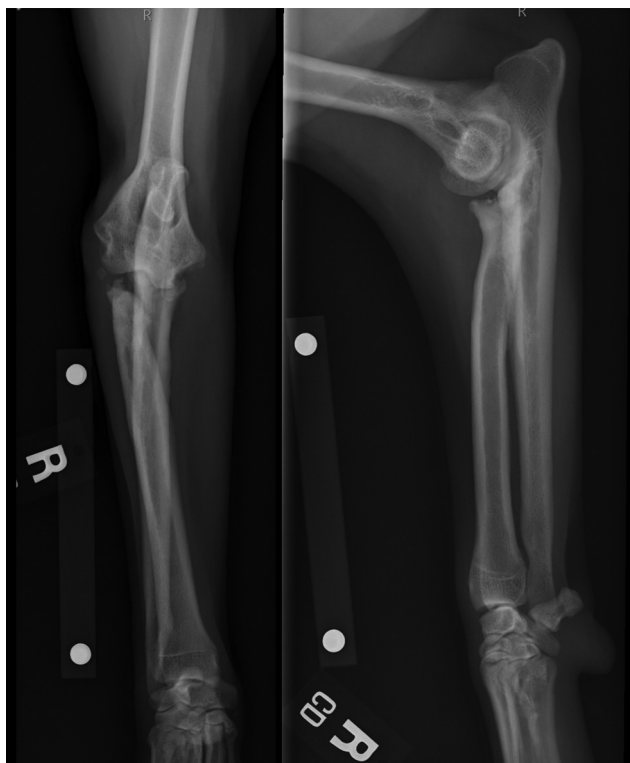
One-year postoperative radiographs of previously operated (right) elbow.
